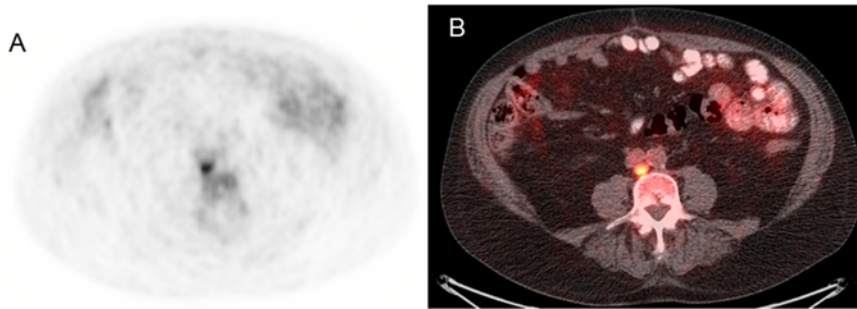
73 year old male with biochemical recurrence of prostate cancer after prostatectomy and lymphadenectomy (PSA of 1.02 ng/mL; doubling time of 4.5 months). ¹⁸F-fluciclovine PET-CT found a single 0.9 cm retrocaval lymph node with SUV > bone marrow. Transaxial (A) PET, (B) fused PET-CT. Surgical excision was positive for metastasis and subsequent PSA nadir (0.08 ng/mL)
